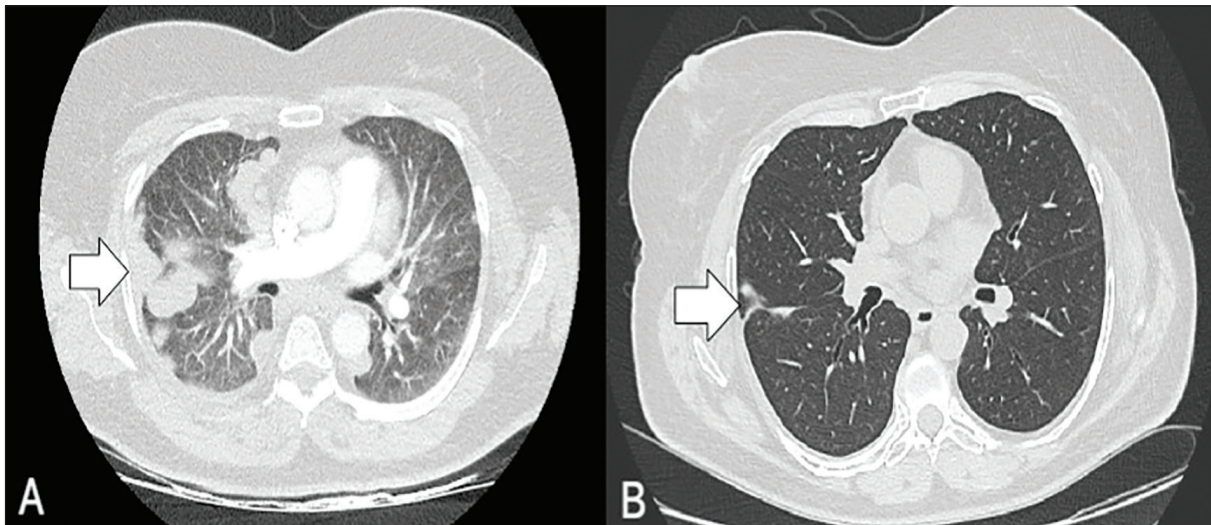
Axial CT scan of the chest demonstrating multiple peripheral lung nodules, as per MPE metastases (white arrow - panel A). Axial CT scan of the chest following 5 cycles of chemotherapy with temozolomide showing a significant disease response (white arrow - panel B).
